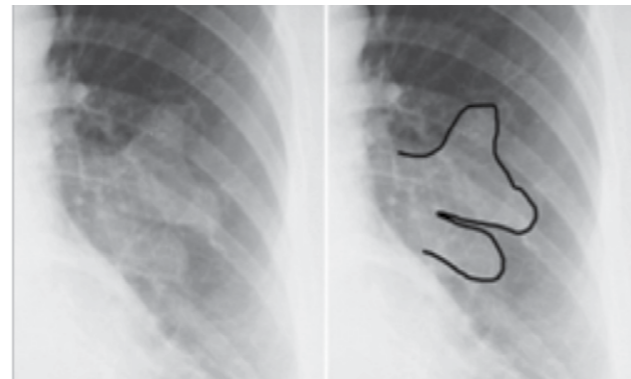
Radiographic appearance of a bronchocoele (outlined in black). Reproduced with permission from Martinez et al. 2008.²
